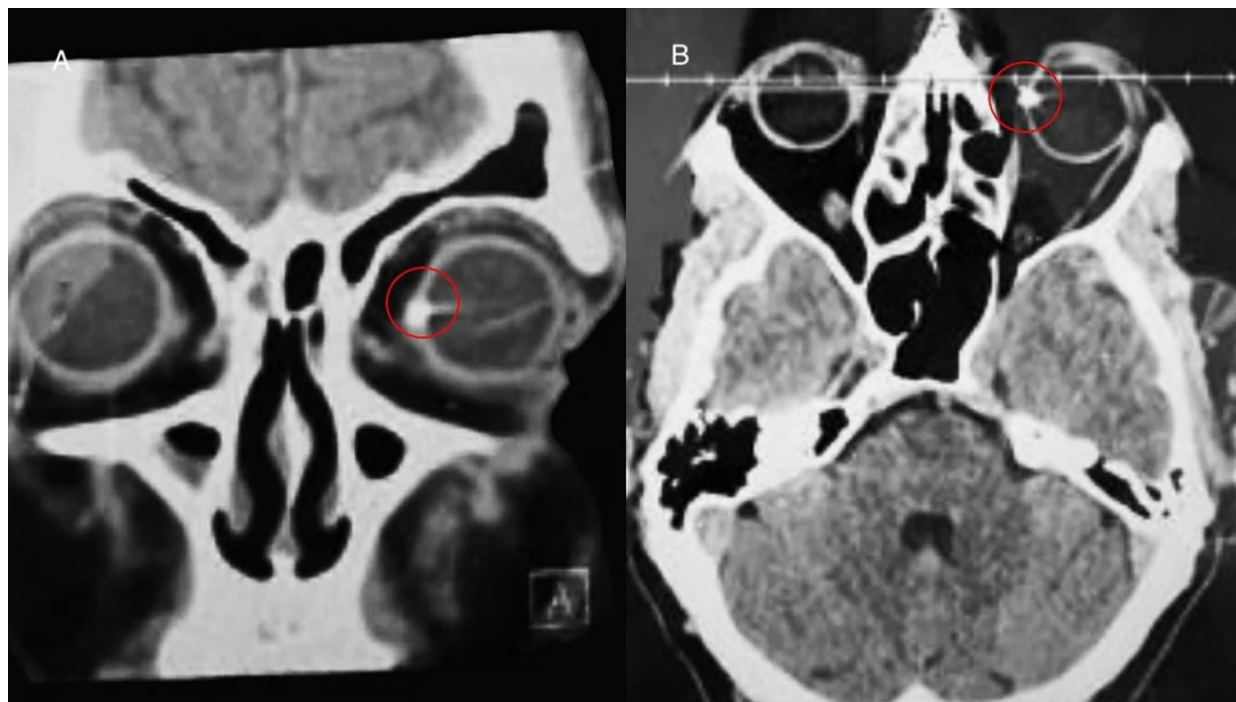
Computed tomography of the orbits revealed a small metallic foreign body embedded in the anterior sclera.
